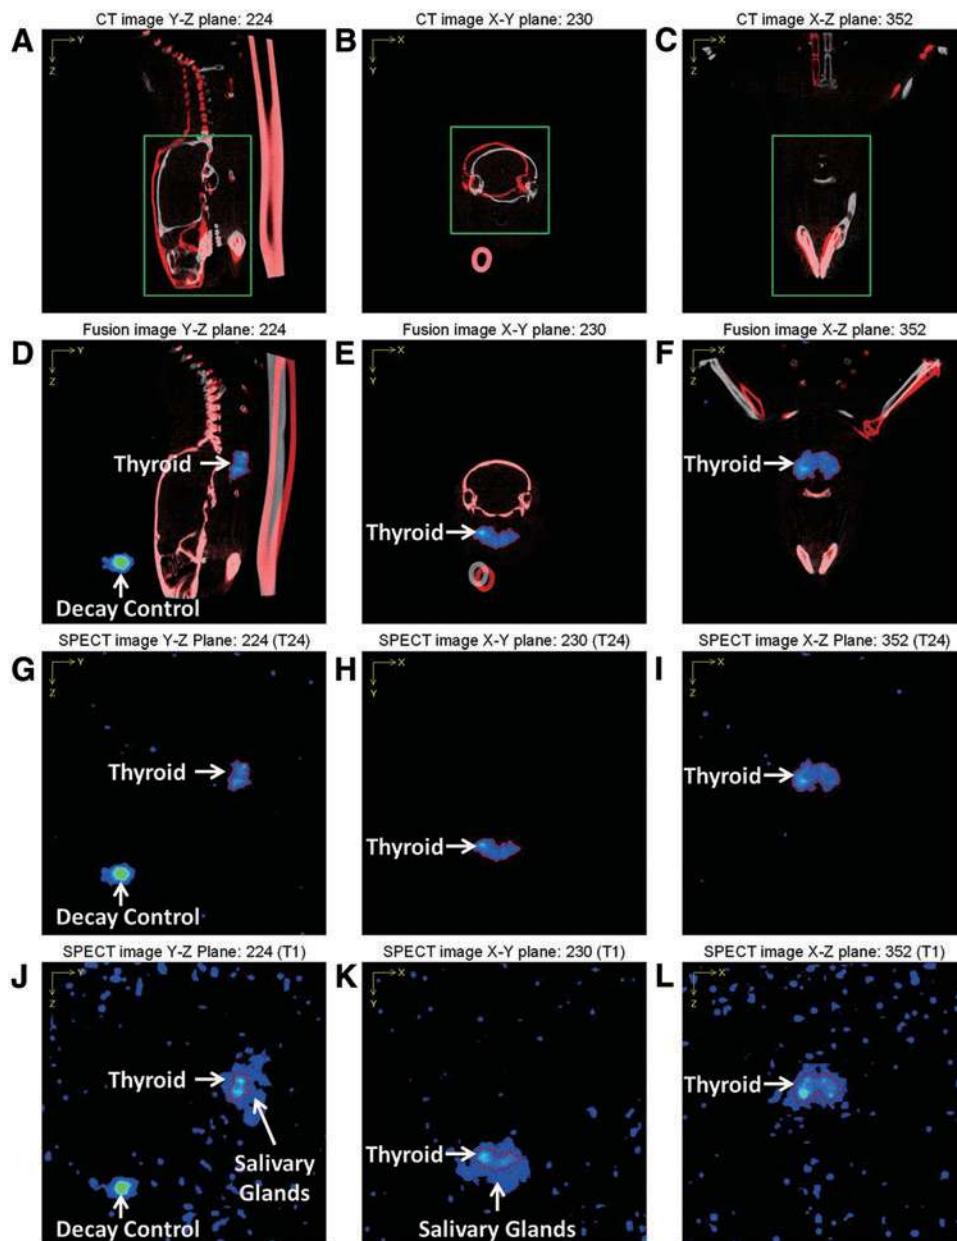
Automatic segmentation of thyroid volume of interest (VOI) on t1 image via superimposing thyroid VOI from t24 SPECT image. MicroSPECT/CT images are acquired at 1 h (t1) and 24 h (t24) post ^{123}I injection. The sagittal (A and D), transaxial (B and E), and coronal (C and F) views of a t1 CT image (shown in red) and a t24 CT image (shown in white) prior to (A–C) and after (D–F) alignment are shown. (G–I) The sagittal (G), transaxial (H), and coronal (I) views of the thyroid VOI (perimeter in red) on the t24 SPECT image. (J–L) The sagittal (J), transaxial (K), and coronal (L) views of the thyroid VOI from the t24 image (perimeter in red) superimposed on the t1 SPECT image. The decay control is also shown in (D), (G), and (J). Color images available online at www.liebertpub.com/thy
